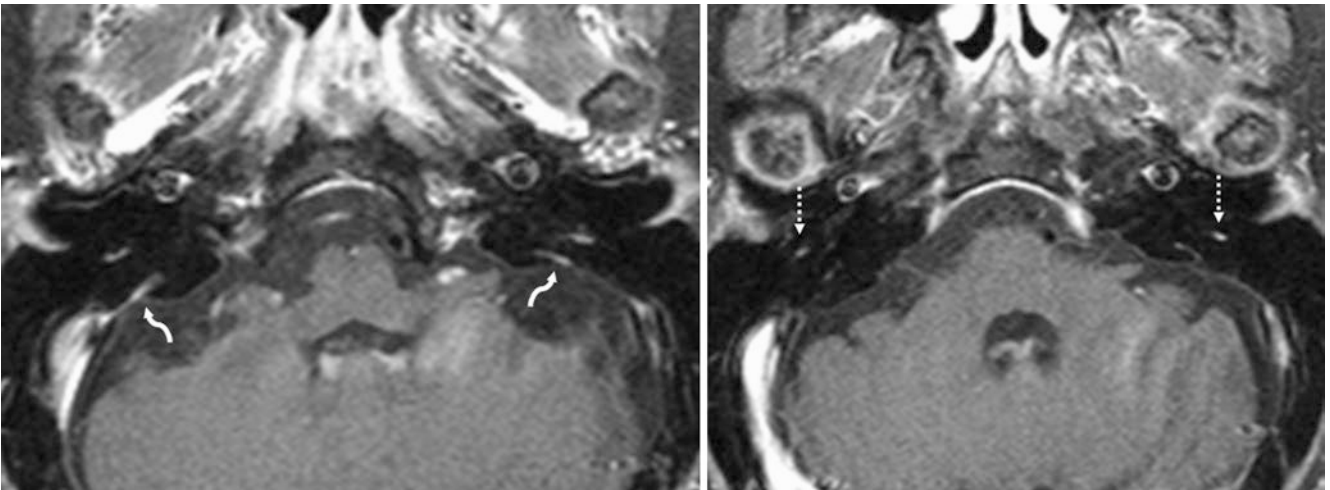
Another 55 year old (different patient than the previous one) with a negative 1.5 T MRI for hearing loss. There is bilateral mild to moderate VA enhancement (*curved arrows*). Also, note enhancement of the descending (mastoid) segments of CN7 bilaterally (*dotted arrows*)
